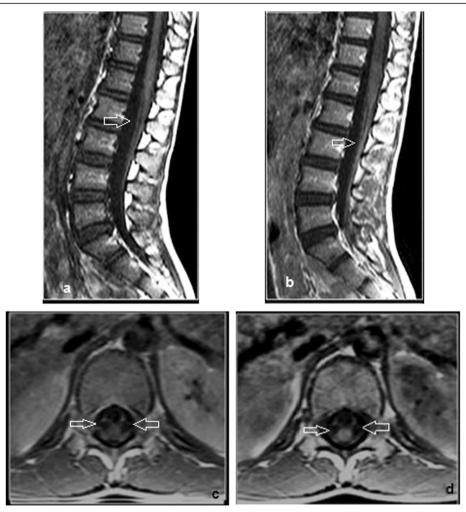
MRI demonstrates a, c sagittal and axial T1W show mildly thickened cauda equina nerve roots. b, d Sagittal and axial post-contrast T1W show anterior and posterior nerve roots of the cauda equina, pattern 3 of contrast enhancement
